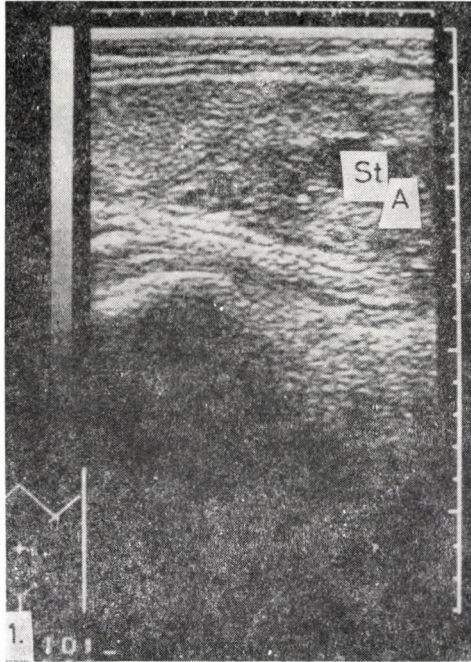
Ultrasonography. Longitudinal section of fetus revealed ascites distending the abdomen (A), distension of the stomach (st) and conglomeration of the intestines
